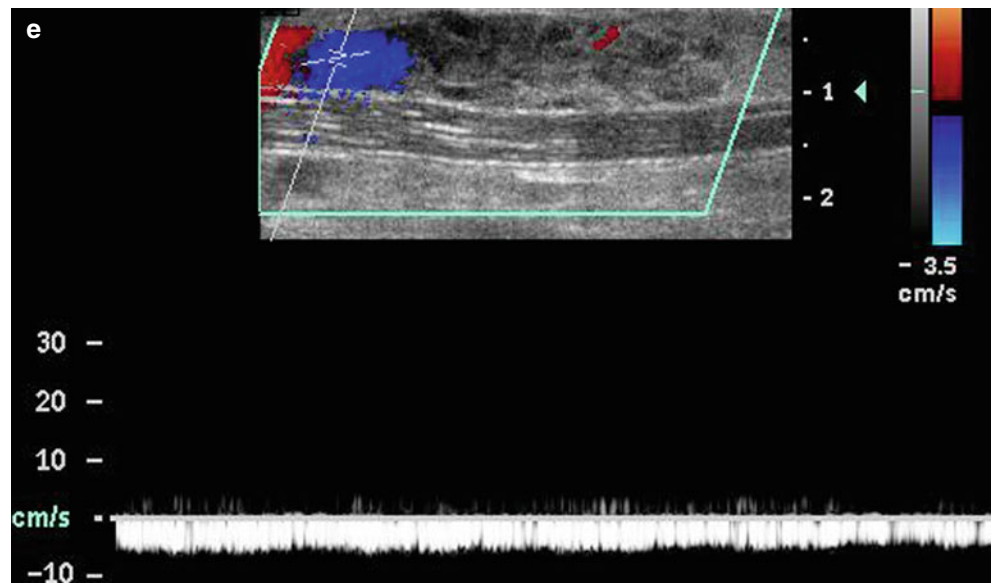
Grey scale ultrasound image of a patient with a venous malformation at the distal thigh consisting of thin walled anechoic sponge-like caverns
